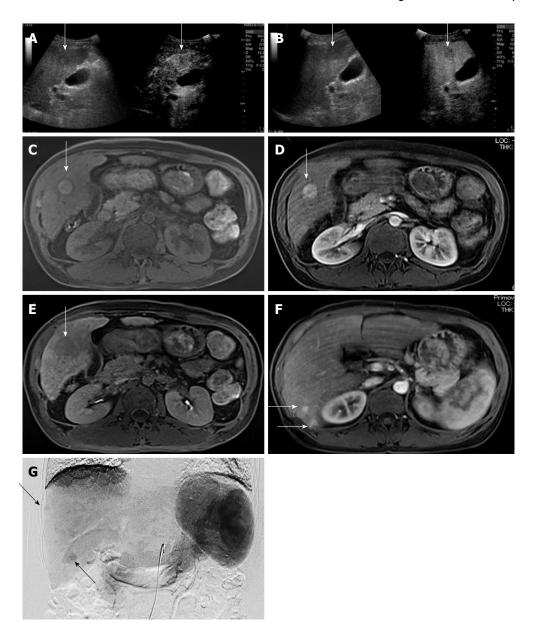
Images of Case 2. Contrast-enhanced ultrasonography: A: The vascular arterial phase; B: The Kupffer phase; EOB-MRI: C: T1-weighted MRI image; D: The arterial phase; E: The hepatobiliary phase of EOB-MRI; F: Several tumorous lesions in the liver besides S5 lesion in the arterial phase of EOB-MRI study; Angiography: G. EOB-MRI: Gd-EOB-DTPA-enhanced magnetic resonance imaging.
